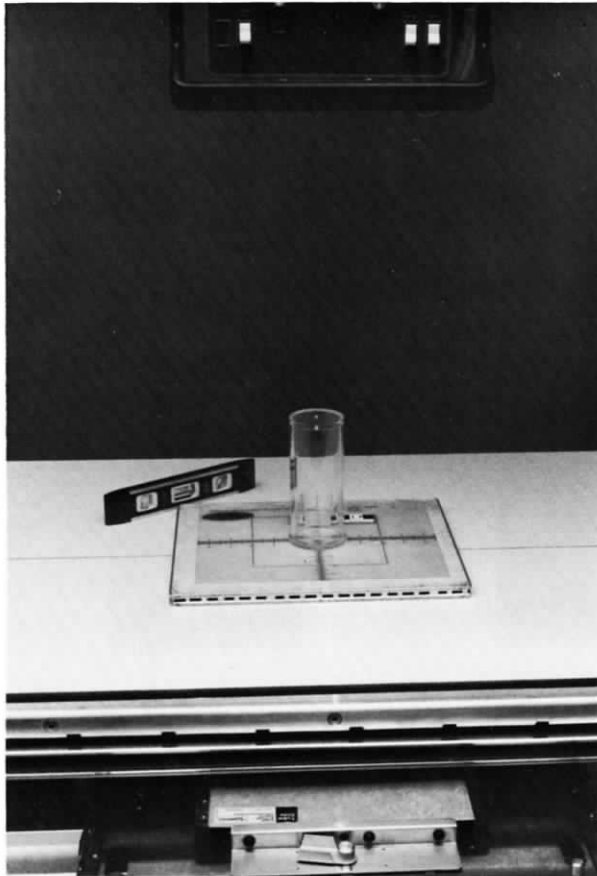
X-ray-light field alignment and x-ray beam perpendicularity test setup.
